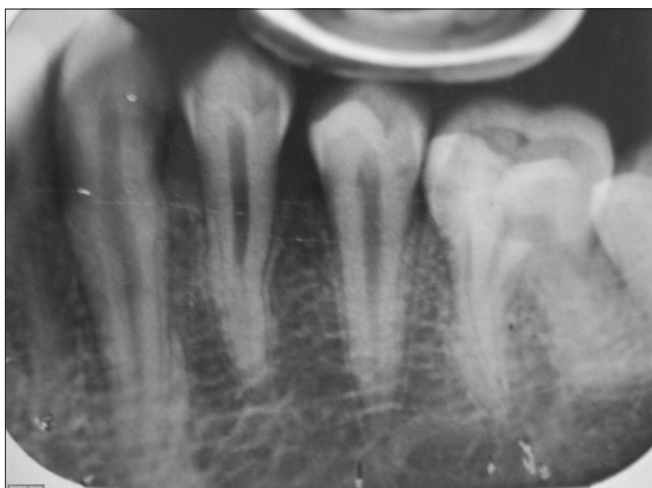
Intraoral periapical radiograph
